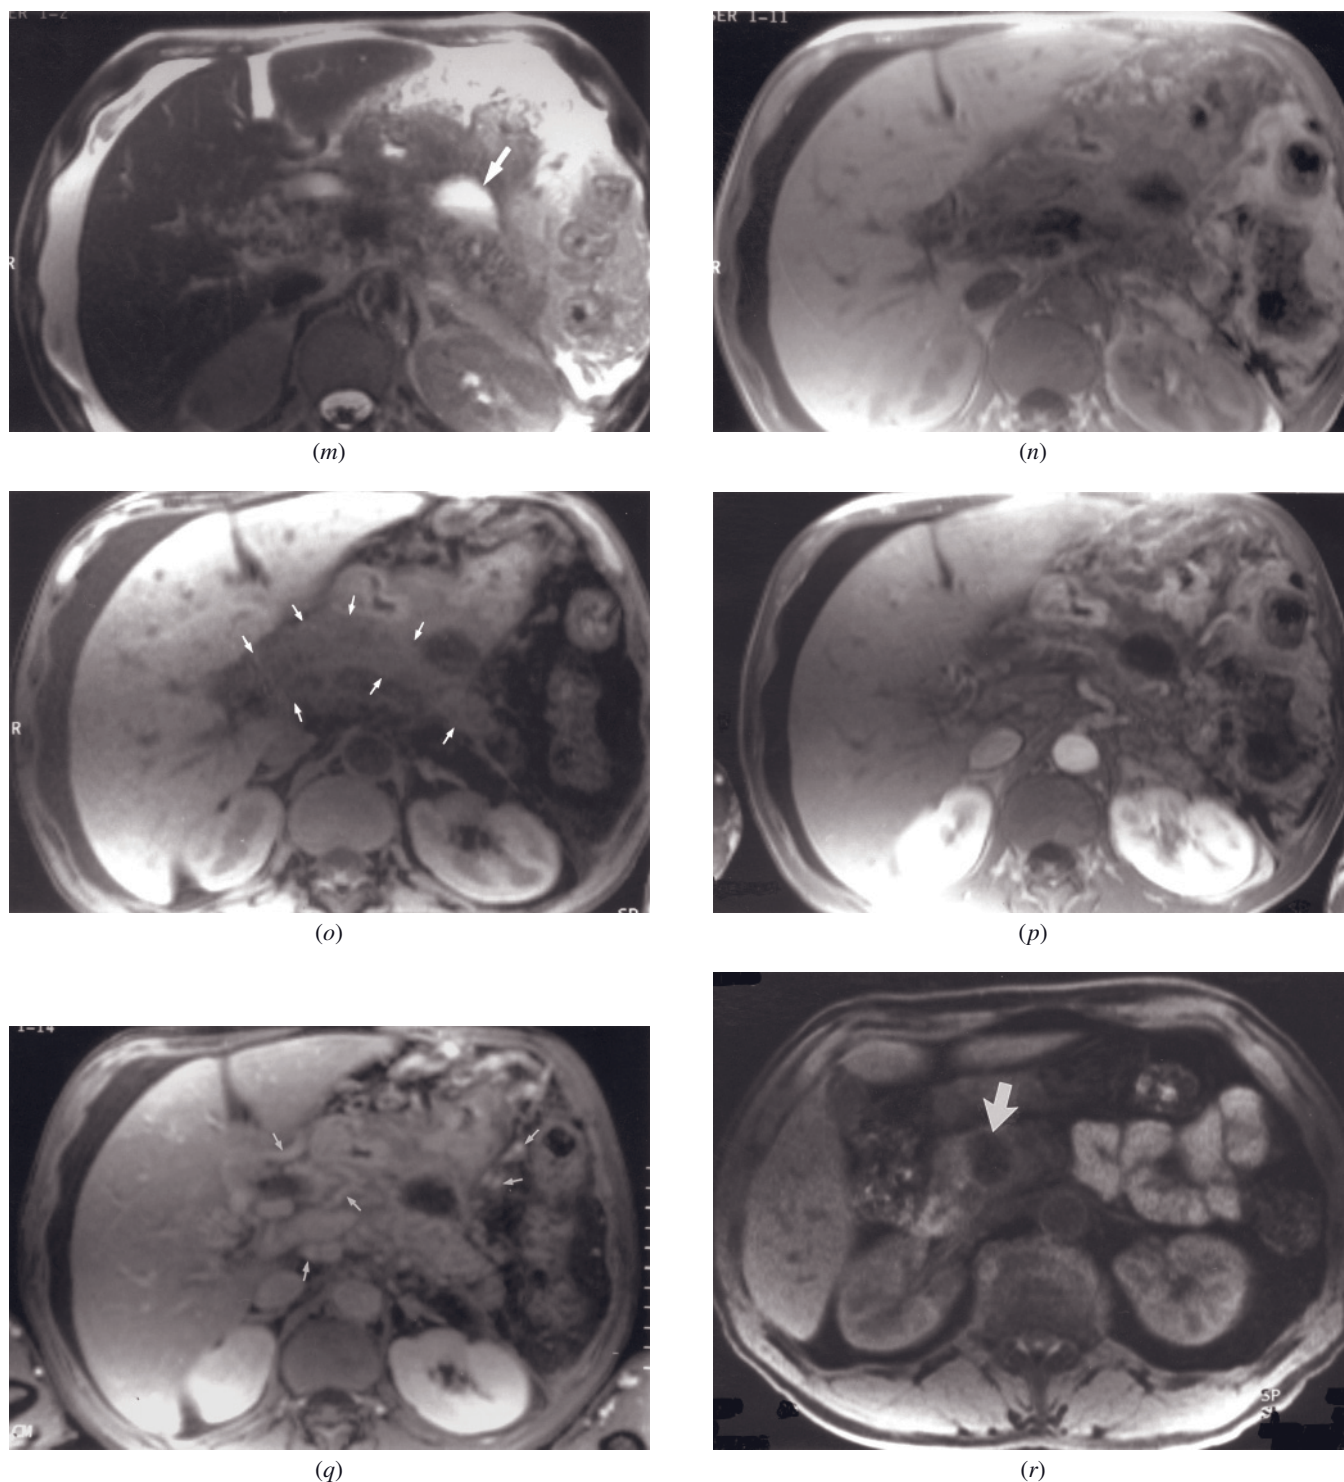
(Continued) T2-weighted echo-train spin-echo (*m*), T1-weighted SGE (*n*), T1-weighted fat-suppressed SGE (*o*), immediate postgadolinium T1 SGE (*p*), and 90-s postgadolinium T1-weighted fat-suppressed SGE (*q*) images in a third patient. The pancreas is enlarged and ill-defined with blurring of the adjacent fat. The pancreas is low signal (arrows, *o*) on noncontrast T1-weighted fat-suppressed images (*o*) and on immediate postgadolinium SGE images (*q*) consistent with chronic pancreatitis. The pancreatic parenchyma shows progressive enhancement on late gadolinium-enhanced images (*q*), which is also a feature of chronic pancreatitis. There is a thick-walled pseudocyst anterior to the distal body of the pancreas, which contains a fluid-fluid level (arrow, *m*) on T2 (*m*). Multiple varices (small arrows, *q*) observed on the interstitial-phase gadolinium-enhanced image (*q*) reflect thrombosis of the splenic vein from longstanding severe chronic pancreatitis. T1-weighted fat-suppressed SGE (*r*), immediate postgadolinium
